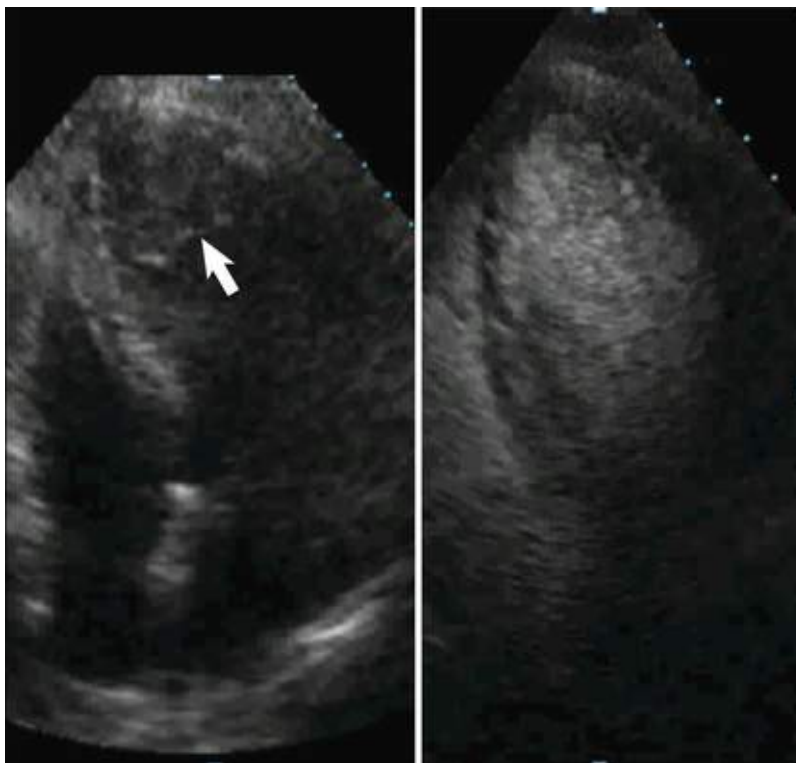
Apical four-chamber unenhanced (left) and contrast-enhanced (right) images. In the unenhanced image a thrombus-like structure is visualized in the apical region (*arrow*). The enhanced version shows that there is no filling defect, thus suggesting that this was an acoustic artifact and not a true thrombus.
